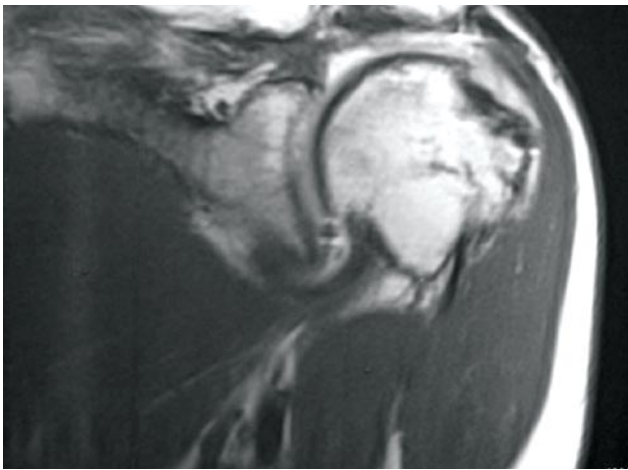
Two years after small intestine submucosa (SIS) was used to bridge defect, coronal magnetic resonance imaging (MRI) shows thin cuff-like tissue spanning defect. MRI also shows that SIS did not reconstitute into normal healthy rotator cuff tendon but covers humeral head.
